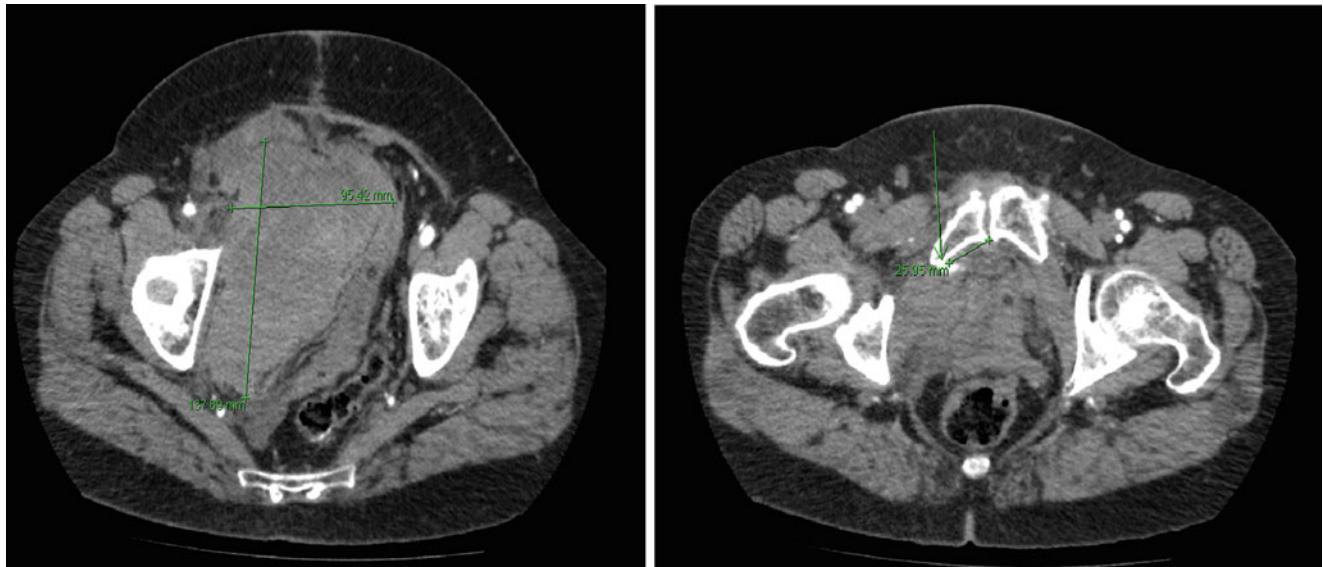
CT scan of retrosymphytic haematoma of 95×137 mm (left), active bleeding at 26-mm distance from the symphysis = corona mortis (right)
